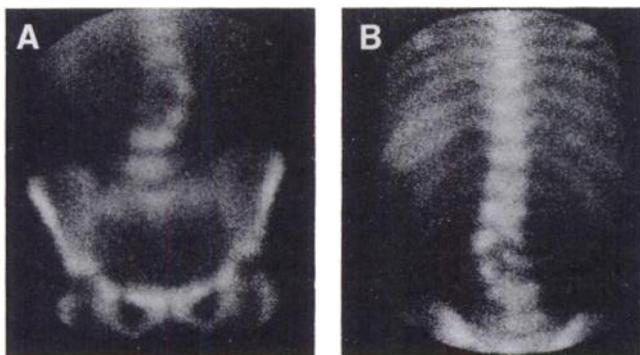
False-negative ^{99m}Tc-AGAB scan ("cold lesion") of a patient with a history of suspected spondylodiscitis and pain. X-ray and T-CT showed destruction of lumbar vertebra 2 and 3 and biopsy-confirmed spondylitis and paravertebral abscess with *E. coli* bacteria. (A) Ventral view and (B) dorsal view.
